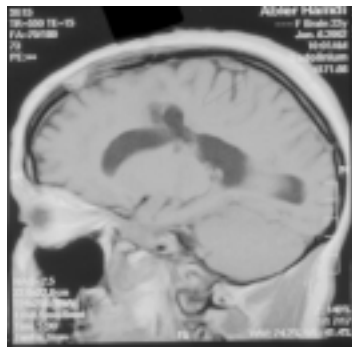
Patient 2, CT scan after treatment.
